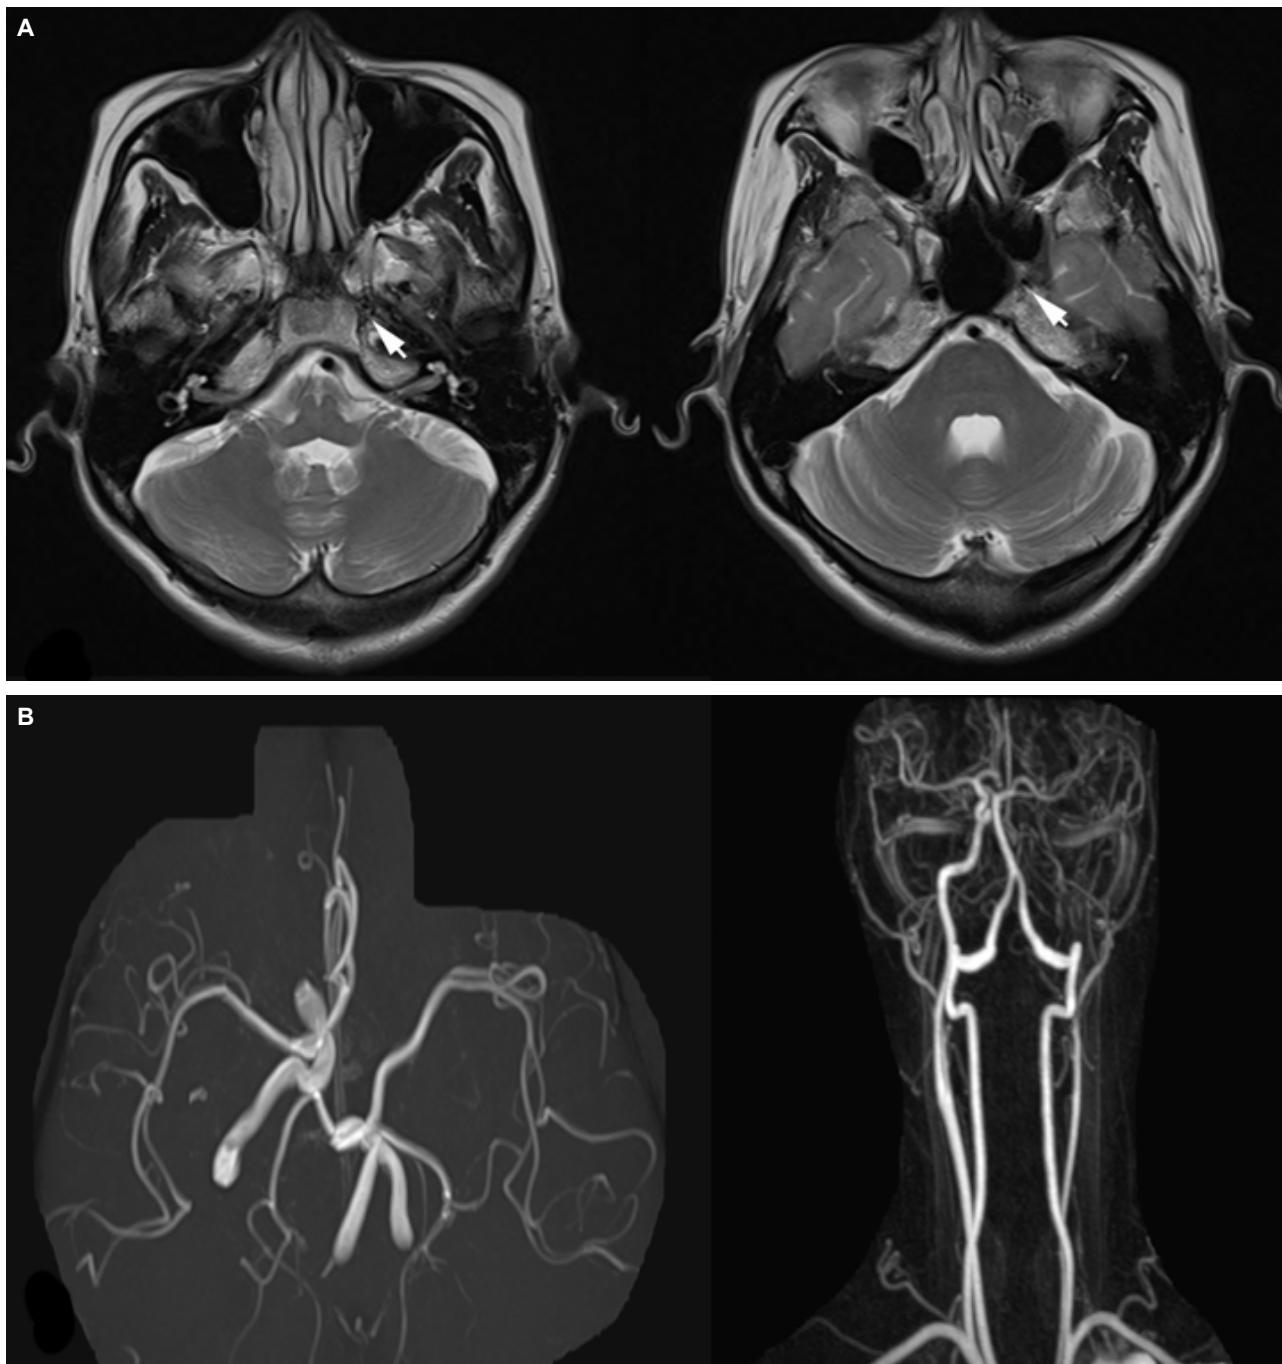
(A) Brain MRI shows absence of the bony carotid canal and petrous portions of the ICA (arrow), suggesting ICA agenesis. (B) MR angiography reveals the left CCA terminating into the ECA with absence of the ICA. Filling of the left anterior circulation by way of the posterior communicating artery and anterior communicating artery is also seen.
